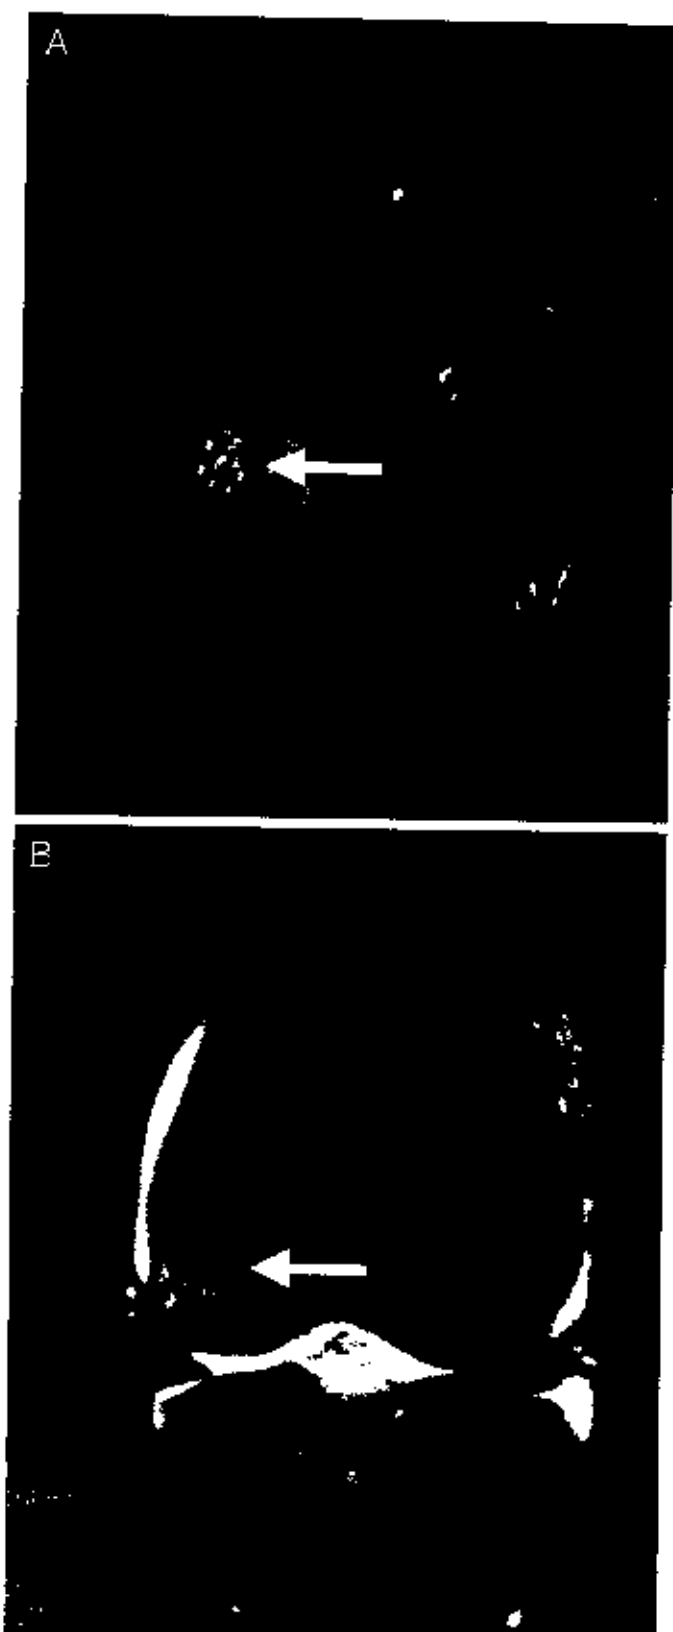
A, sagittal view of a geographic fracture, T2-weighted scan. B, coronal view of a geographic fracture, T2-weighted scan.
